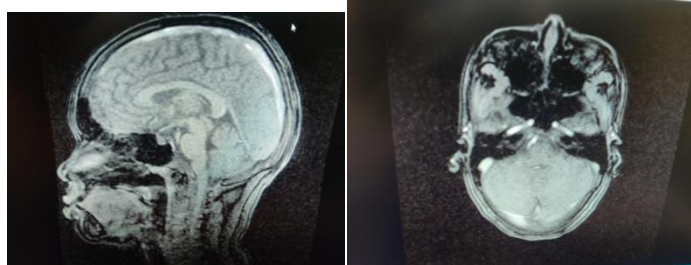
MRI Brain showing bilateral subdural collection in temporo occipital region
